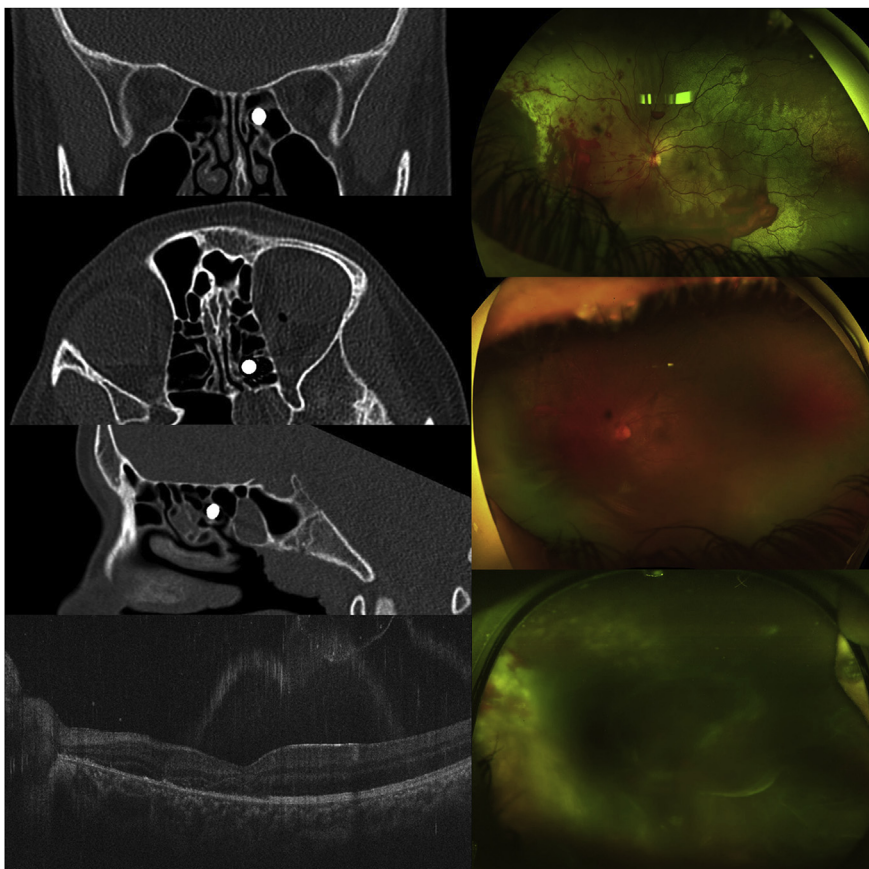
A 13-year-old male was shot near his left eye with a BB gun. Computed tomography scan on presentation showed a metallic BB in the posterior left ethmoid air cells with mild irregularity of the left lamina papyracea (Top left, Middle left). Optical coherence tomography showed disruption and irregularity of the outer macula (Bottom left). Optos ultra wide-field imaging at presentation (Top right), five weeks (Middle right), and eleven weeks (Bottom right) showed nasal choroidal hemorrhage with underlying sclopetaria, commotio retinae throughout the macula and periphery, and a large vitreous hemorrhage inferiorly and nasally that subsequently evolved into dense vitreous hemorrhage.
